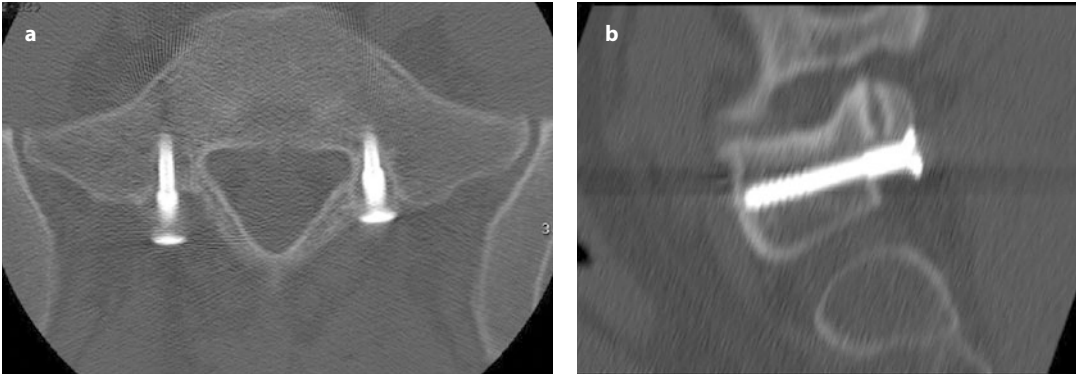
MRI images showing the screw-based PercuDyn system: titanium screws are anchored in the S1 pedicles (a), whereas the polycarbonate-urethane heads of the screws support and cushion the inferior facet complex of the upper metamer (b), thereby limiting its extension and unloading the disk
